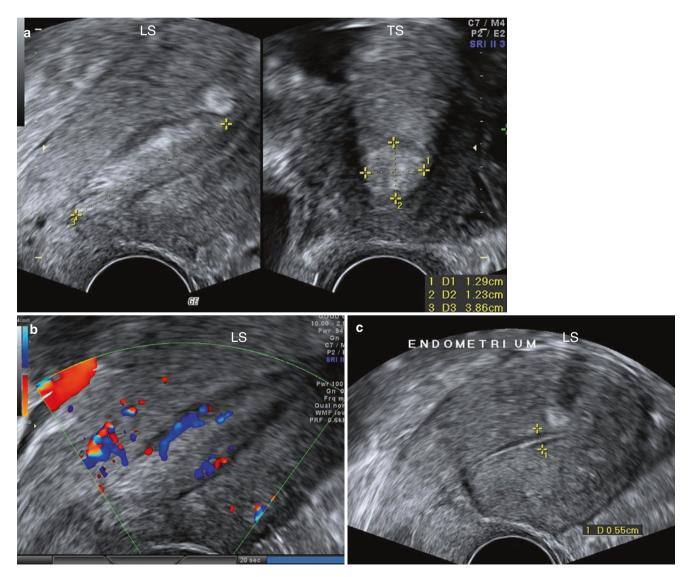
(a) Hyperechoic clot filling the endometrial cavity in a menstruating patient complaining of menorrhagia, which can raise a suspicion of a fleshy endometrial polyp. (b) Flow seen on colour Doppler is the menstrual flow. This raises a false suspicion of flow within an endometrial polyp. (c) Empty uterine cavity noted the next day, confirming the diagnosis of a clot in the endometrial cavity the previous day
